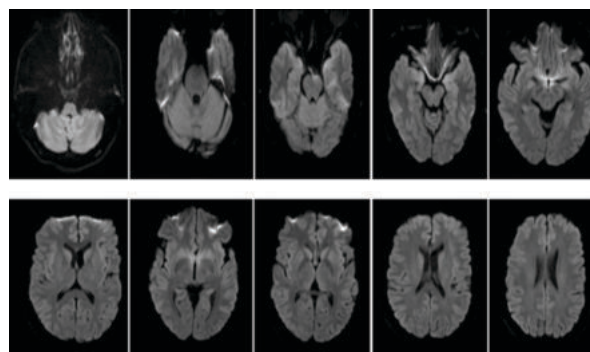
displays an axial section of an MRI brain scan, showing normal diffusion-weighted images.
